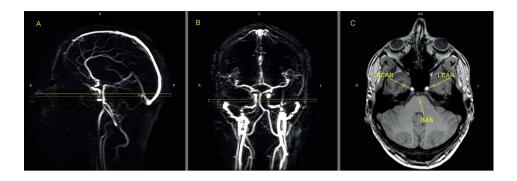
MR images of the vasculature measured with phase contrast MR angiography imaging for Quantitive Flow (QF).
